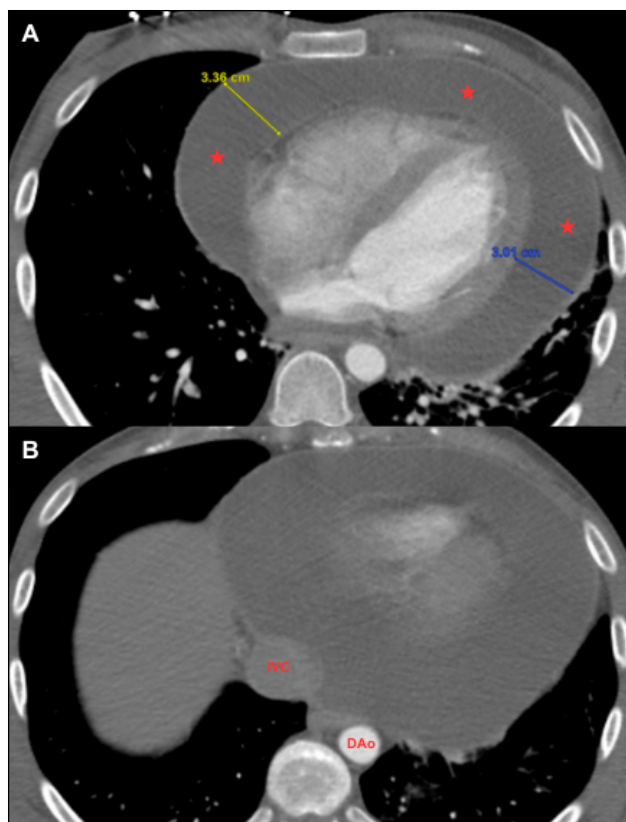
Computed tomography (CT) assessment of pericardial effusion. (A) Contrast-enhanced CT (axial view) demonstrating a large circumferential pericardial effusion (marked as ★) with simple fluid attenuation (0-20 Hounsfield units) suggestive of transudative process. (B) Similar patient's CT showing dilated inferior vena cava, suggesting elevated right atrial pressure.
